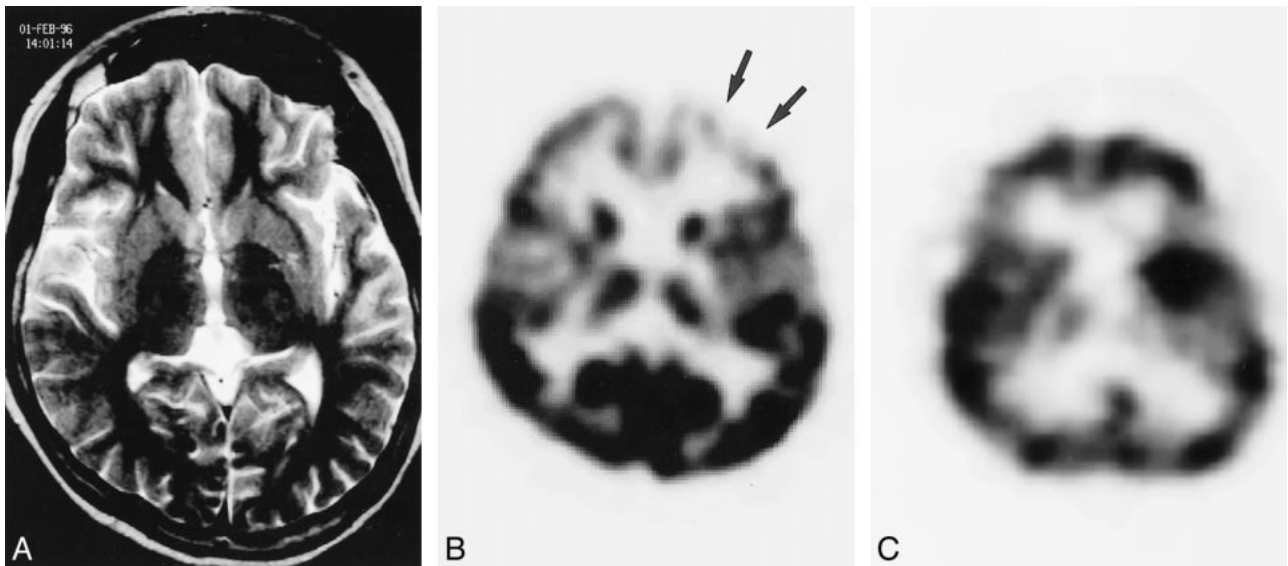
False-negative MR imaging and ictal SPECT findings for an 18-year-old female patient with left frontal lobe epilepsy. A, Axial fast spin-echo T2-weighted (6000/90) MR image shows no diagnostic abnormality. B, FDG PET scan shows focal hypometabolism in the left frontal cortex (arrows). C, Ictal SPECT scan fails to show hyperperfusion in any area. Lesion-like increased uptake in the left basal ganglia is due to asymmetrical reconstruction of the image. Invasive EEG study detected ictal activity originating from the left frontal lobe. After neocortical resection, the pathologic diagnosis was microdysgenesis. Engel's outcome was class IV.
